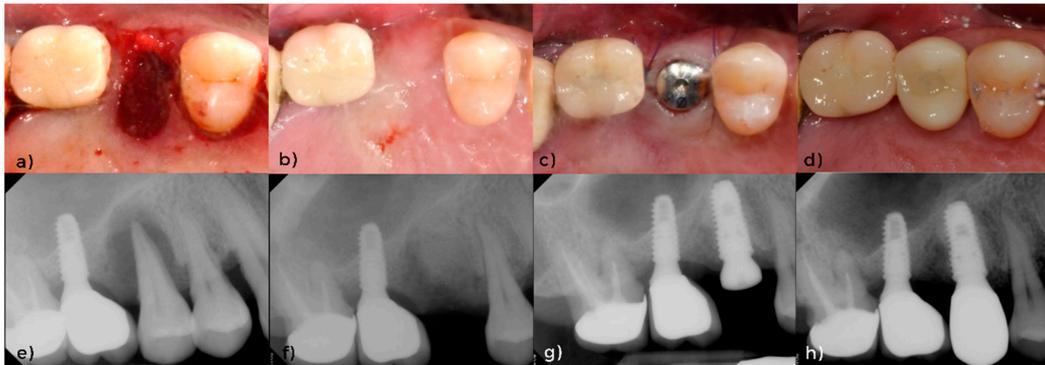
Clinical photos and peri-apical radiographs of Case I. Clinical photos of (a) after extraction, (b) one year after alveolar ridge preservation (ARP), (c) after implantation, (d) after prosthesis delivery. Peri-apical radiographs of (e) before extraction, (f) after ARP, (g) after implantation, (h) after prosthesis delivery.
